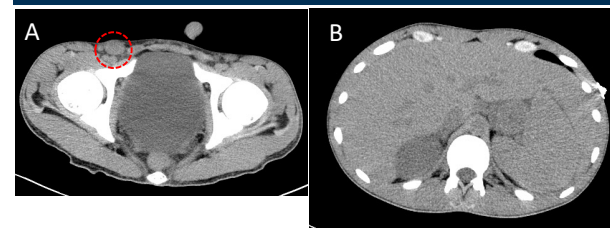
CT Abdomen / Pelvis Without Contrast. Images A and B. Image A demonstrating an enlarged right inguinal lymph node, with short axis measuring 15 mm. Image B demonstrating marked hepatosplenomegaly.
